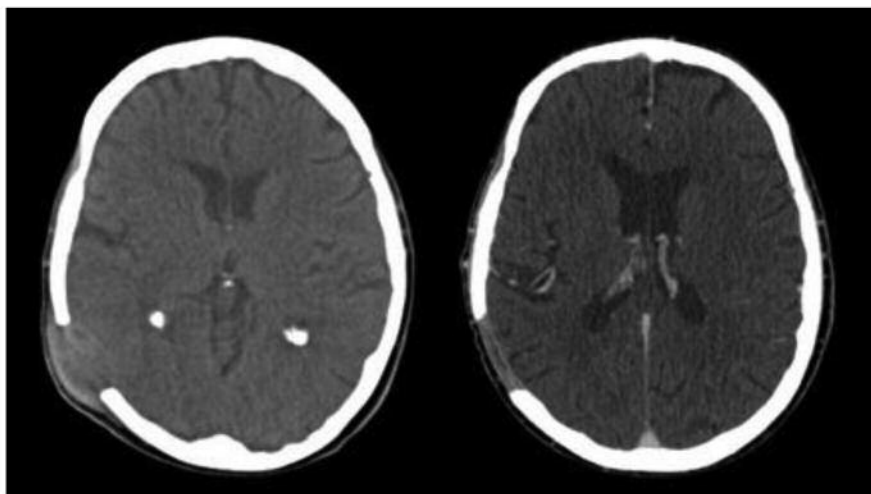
Computed tomography images of the right parietal bone metastasis before (left) and after (right) local radiation therapy.
